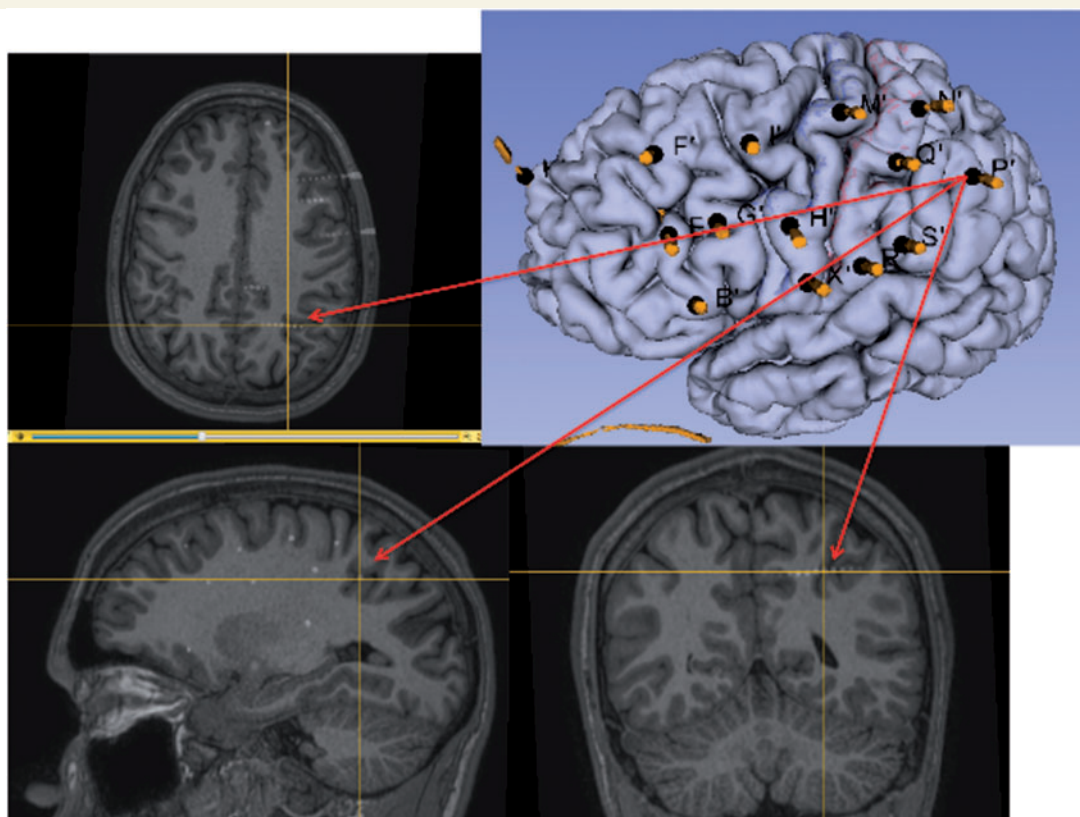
Example of a fronto-centro-parietal left-side implantation with five electrodes sited in the parietal cortex. The following electrodes were implanted in the parietal lobe: N, Q and R = primary sensory area in the postcentral gyrus; S = sovramarginal gyrus; P = angular gyrus with the lateral contacts, intraparietal sulcus in the intermediate part, as shown in the multiplanar magnetic resonance image, and parietal cingulate gyrus with the mesial leads. All other electrodes are sited in the frontal lobe.
